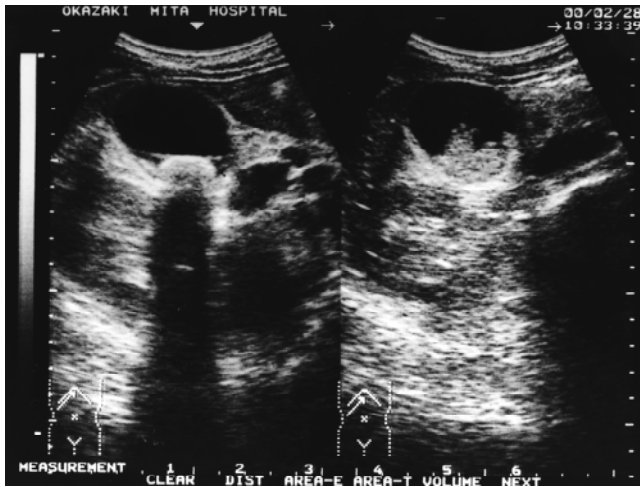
Abdominal ultrasonography conducted at a local hospital, revealing thick-walled gallbladder associated with multiple gallstones (*left*) and bile sludge (*right*), which was depicted as an irregularly shaped high-echoic mass in the gallbladder
